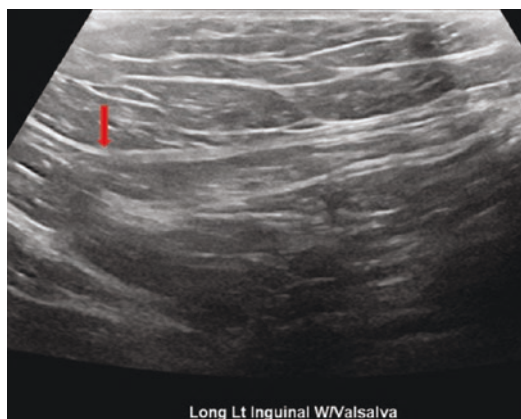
Longitudinal ultrasound image of normal inguinal canal. The head of the patient is towards the left side of the picture. The internal inguinal canal is identified by the arrow
